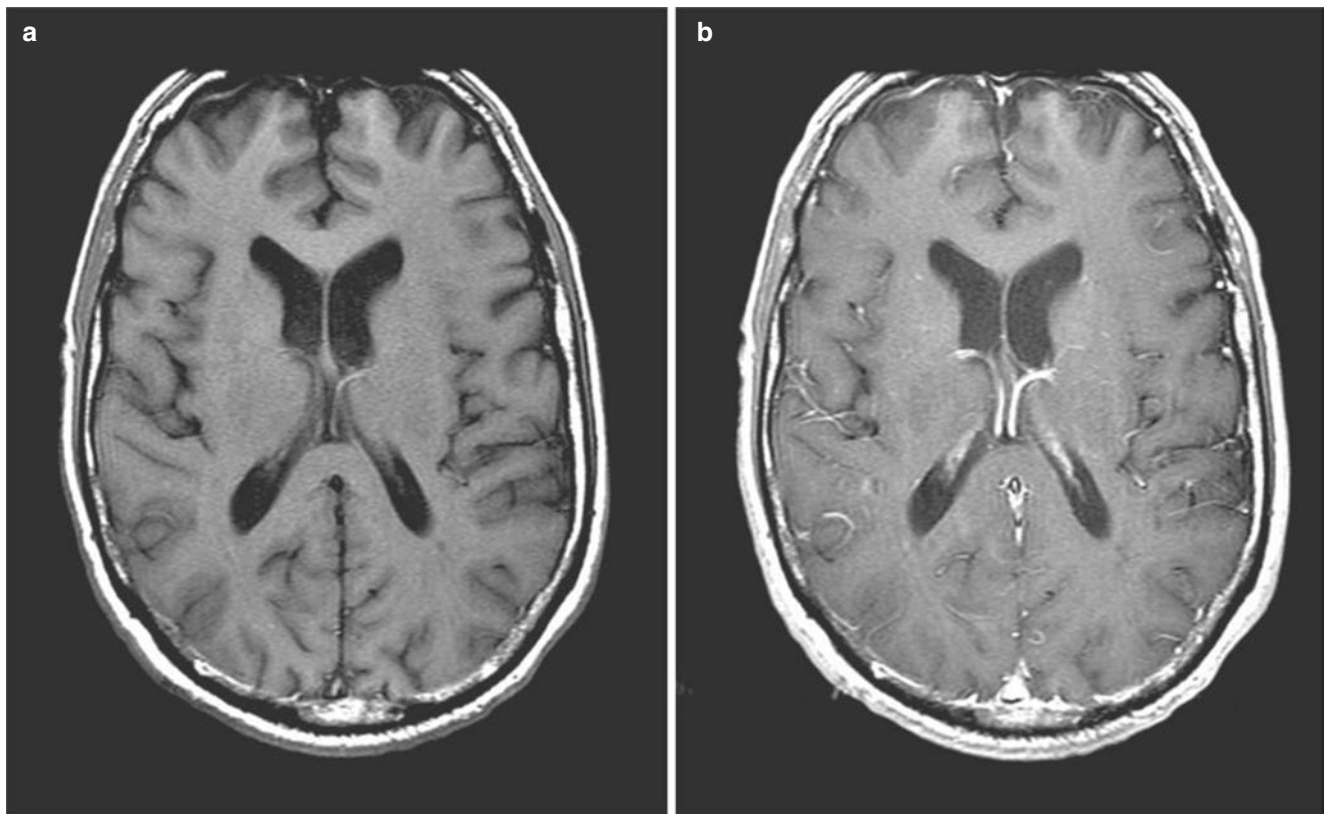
(a) Axial T1, (b) T1 post-contrast, (c) T2, and (d) T2-FLAIR MRI of the brain. On the post-contrast image, vascular structures and the choroid plexus show expected enhancement
